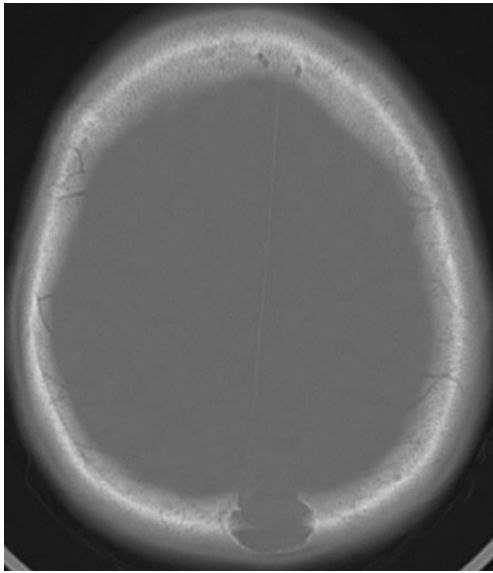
Epidermoid cyst in a 78-year-old woman. CT with bone algorithm shows a fully lucent lesion with a sclerotic margin in the occipital bone
